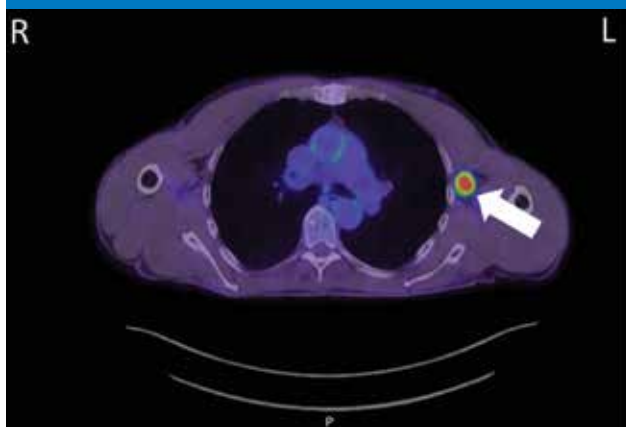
CT PET scan axial view. White arrow pointing to hypermetabolic mass in the left axilla.
